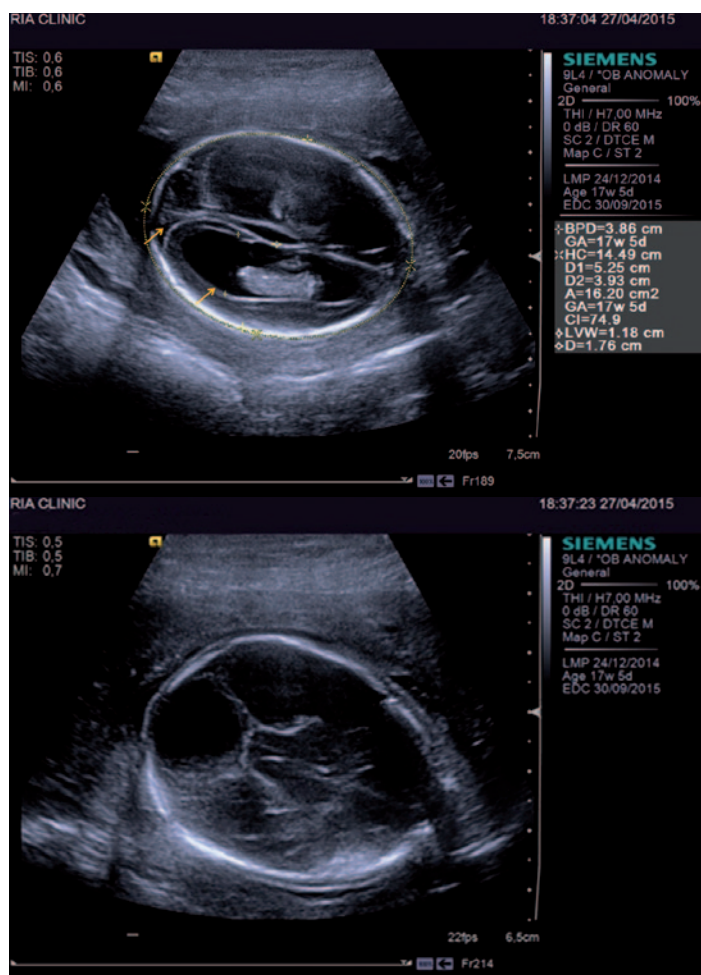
High Resolution neurosonogram with 9L4 probe
